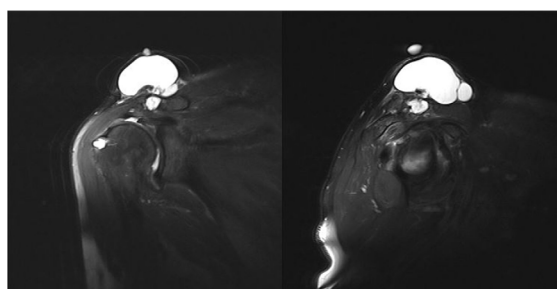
Magnetic resonance imaging of patient.
